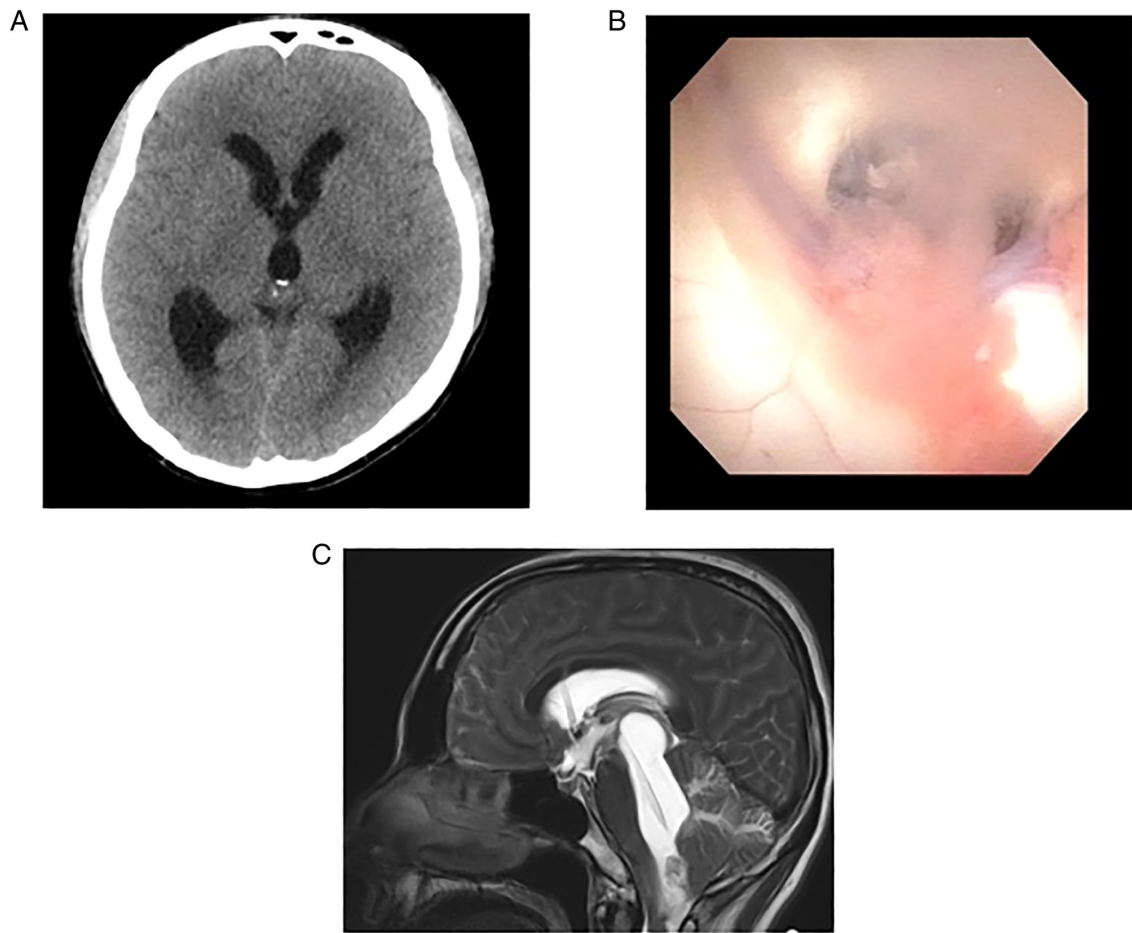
CT after stereotactic radiosurgery, surgical view of endoscopic third ventriculostomy, CT and T2-weighted imaging after VP shunt. (A) CT after stereotactic radiosurgery showed hydrocephalus. (B) Surgical view of endoscopic third ventriculostomy showed that a white membrane-like substance occludes the foramen of Monroe. (C) T2-weighted imaging after VP shunt showed upward herniation due to isolated fourth ventricle. VP, ventriculoperitoneal.
